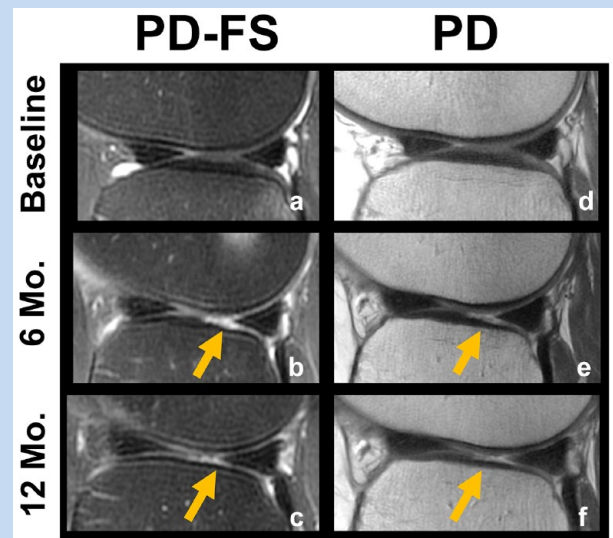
Sagittal fat-suppressed fast-spin echo (a-c) and sagittal fast-spin echo (d-f) MRI sequences of the lateral compartment on a 56-year-old female patient with injured left knee at baseline (a, d), 6 months (b, e), and 1 year (c, f). Images demonstrate progression of articular cartilage injury over the lateral tibial plateau (arrows). PD-FS, proton density-fat saturated.
